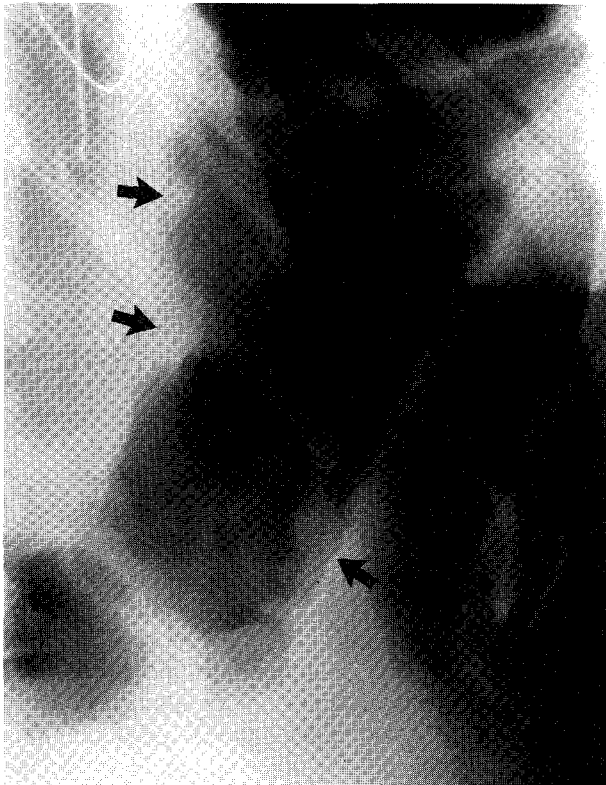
Pseudopolyposis in a patient with ulcerative colitis and symptoms of toxic megacolon. Plain film of the left upper abdomen shows markedly distended and irregular colon, consistent with toxic megacolon. Within the air-filled splenic flexure protruding nodules are seen (arrows).
